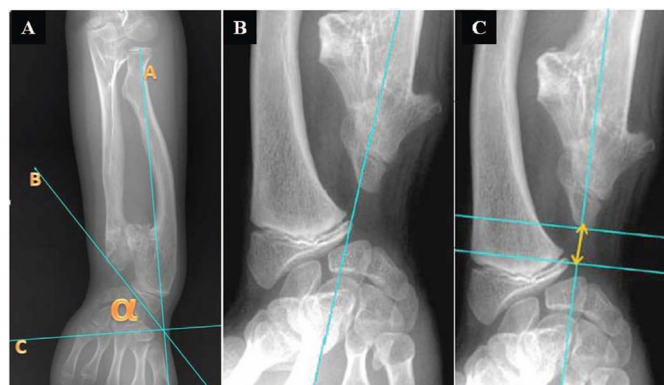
Radiograph parameters as described by Fogel *et al.* (1984) and Burgess and Cates (1993) show (A) RAA (α) was defined as the angle between a line running along the articular surface of the radius (b) and another line (c) that was perpendicular to a line (a) joining the centre of the radial head to the radial border of the distal radial epiphysis (or the radial styloid in skeletally mature patients). (B) CS was measured by determining the percentage of the lunate that is in contact with the radius. A line was drawn from the centre of the olecranon through the ulnar border of the radial epiphysis (or radial articular surface in mature patients). This line normally bisects the lunate. (C) Arrow represents the ulnar variance. We draw a line from the distal ulnar tip to the ulnar border of the distal radial epiphysis. ⁵
